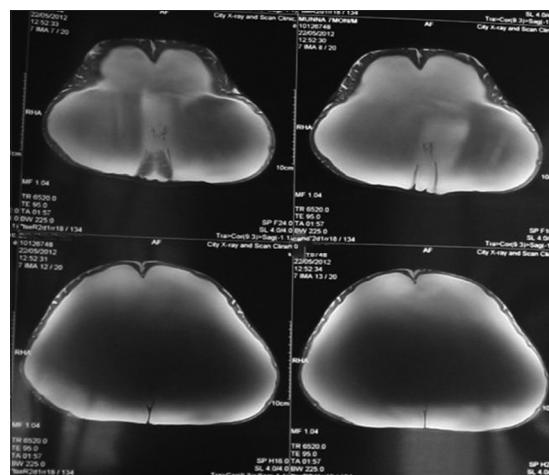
Axial section MRI brain showing ventriculomegaly
